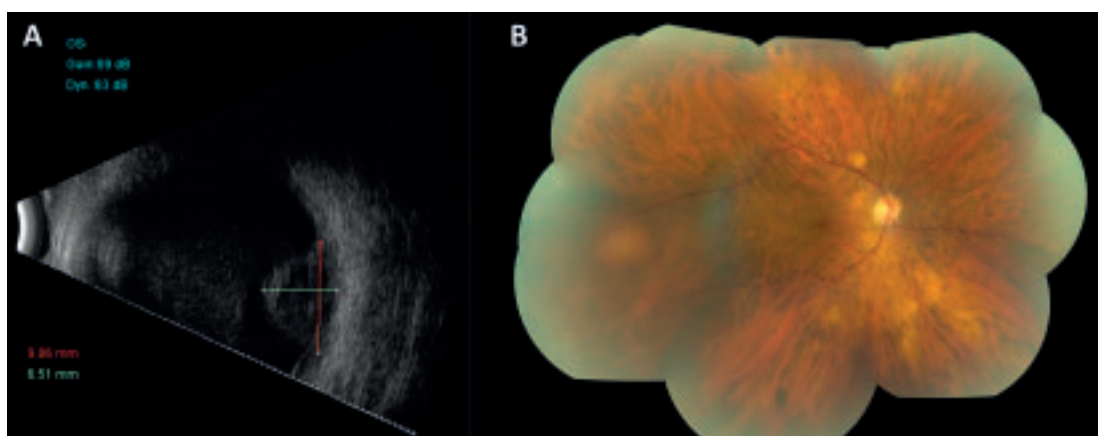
(a) B-scan ultrasound of a metastatic lesion with irregular internal structure in the posterior pole in the left eye. (b) Fundus photography of one yellow asymptomatic lesion in the right eye at the 9 o'clock position.
